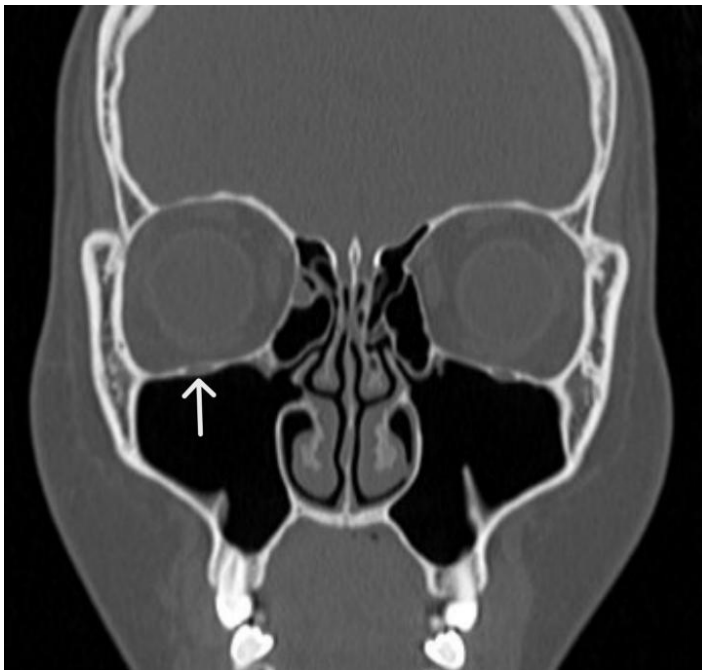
Coronal orbital computed tomography at presentation. The arrow indicates the apparently intact right orbital floor, with no visible evidence of fracture or extraocular muscle entrapment.
